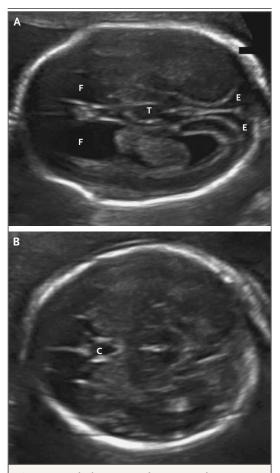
Fetal Ultrasonography at 19 Weeks of Gestation.
